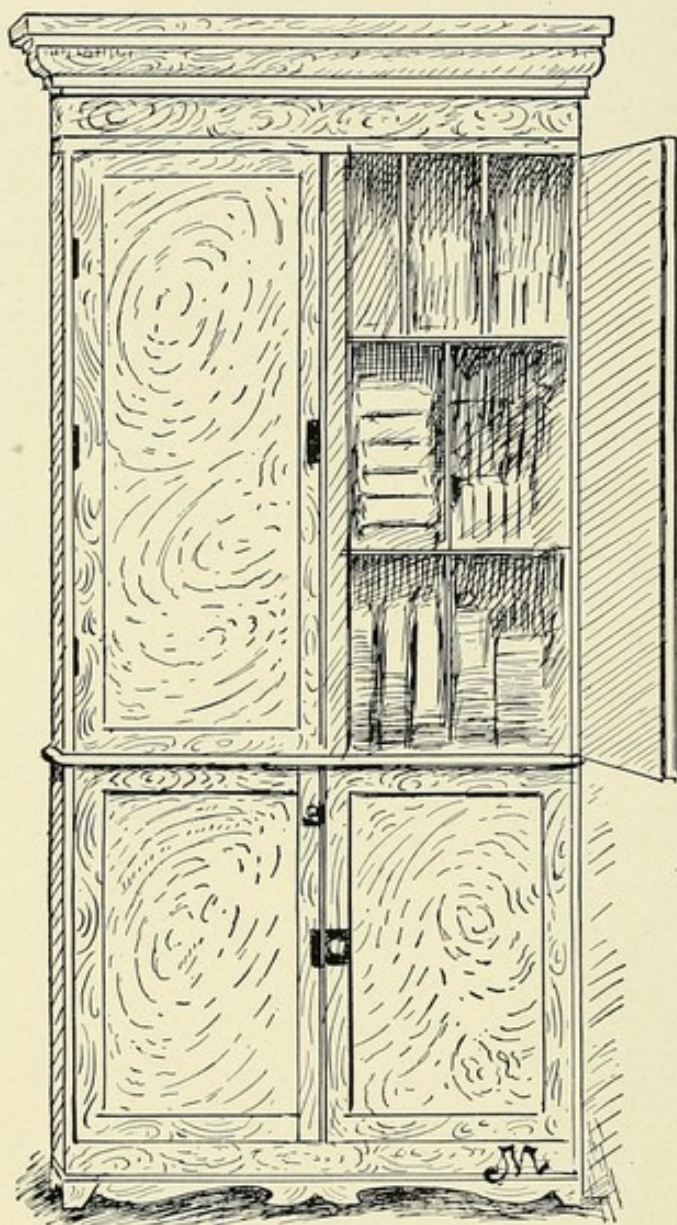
X-ray plate box.
